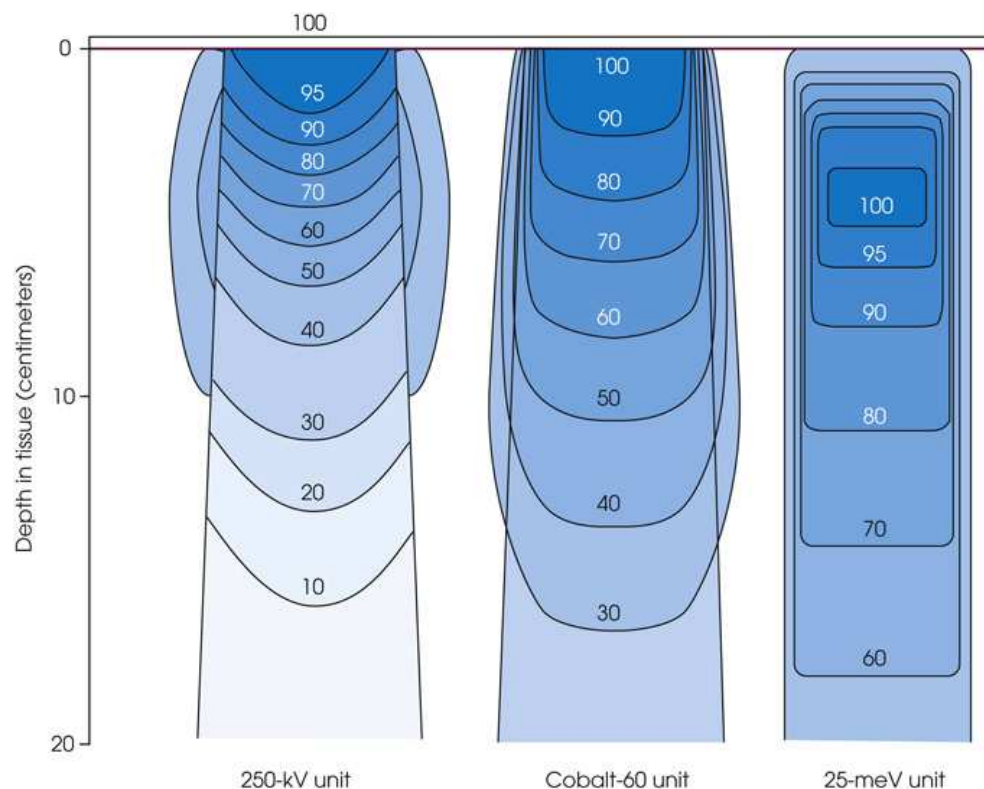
Three isodose curves showing comparison of percent of dose deposition from three x-ray units of different energies. As the energy of the beam increases, the percentage of dose deposited on the surface of the patient decreases.
